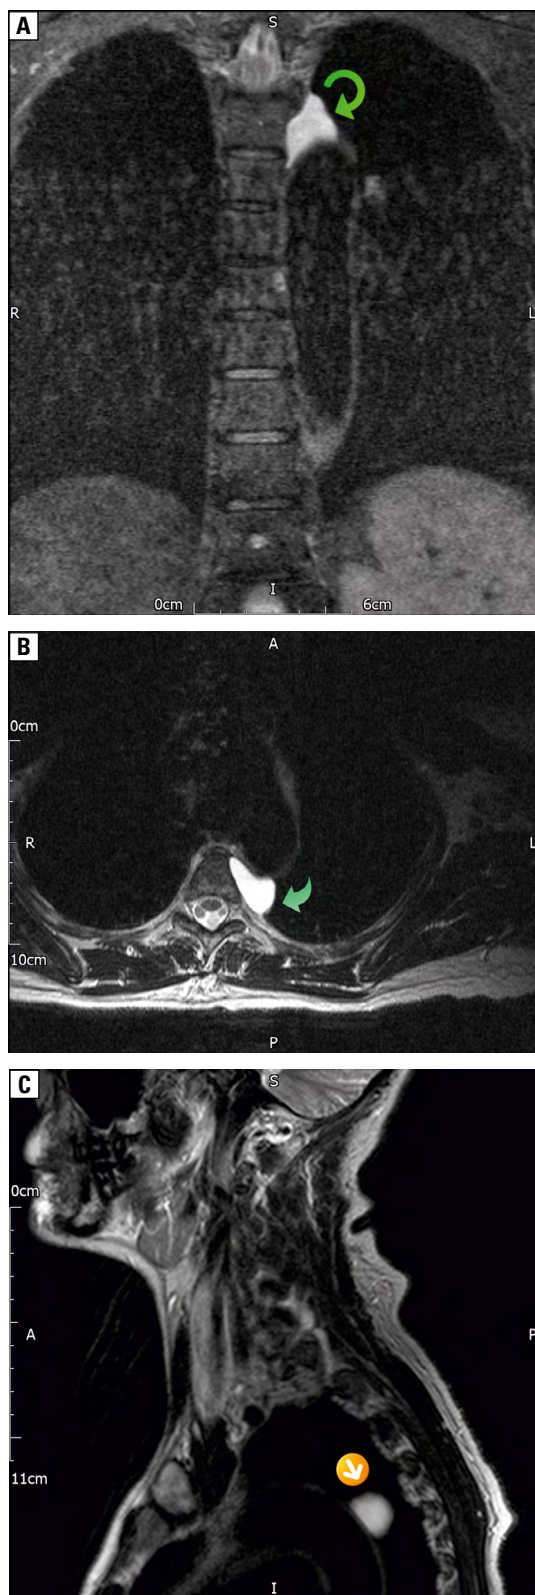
A. Magnetic resonance image (MRI) chest-coronal view; left paravertebral mass of cystic nature seen very close to the aortic arch (green arrow); B. MRI chest-axial view; left paravertebral mass of cystic nature seen very close to the aortic arch (green arrow); C. MRI chest-sagittal view; left paravertebral mass of cystic nature seen very close to the aortic arch (orange arrow)
